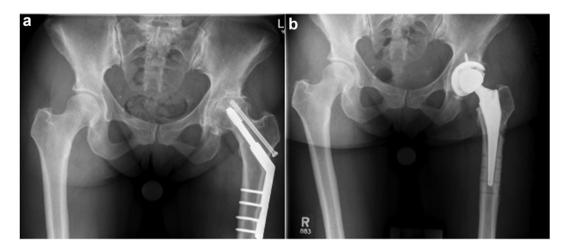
(a) AP radiograph demonstrating post-traumatic arthritis of the left hip following open reduction internal fixation of the left hip. (b) AP radiograph following conversion THA with the ABMS approach with ROH. AP, anteroposterior.
